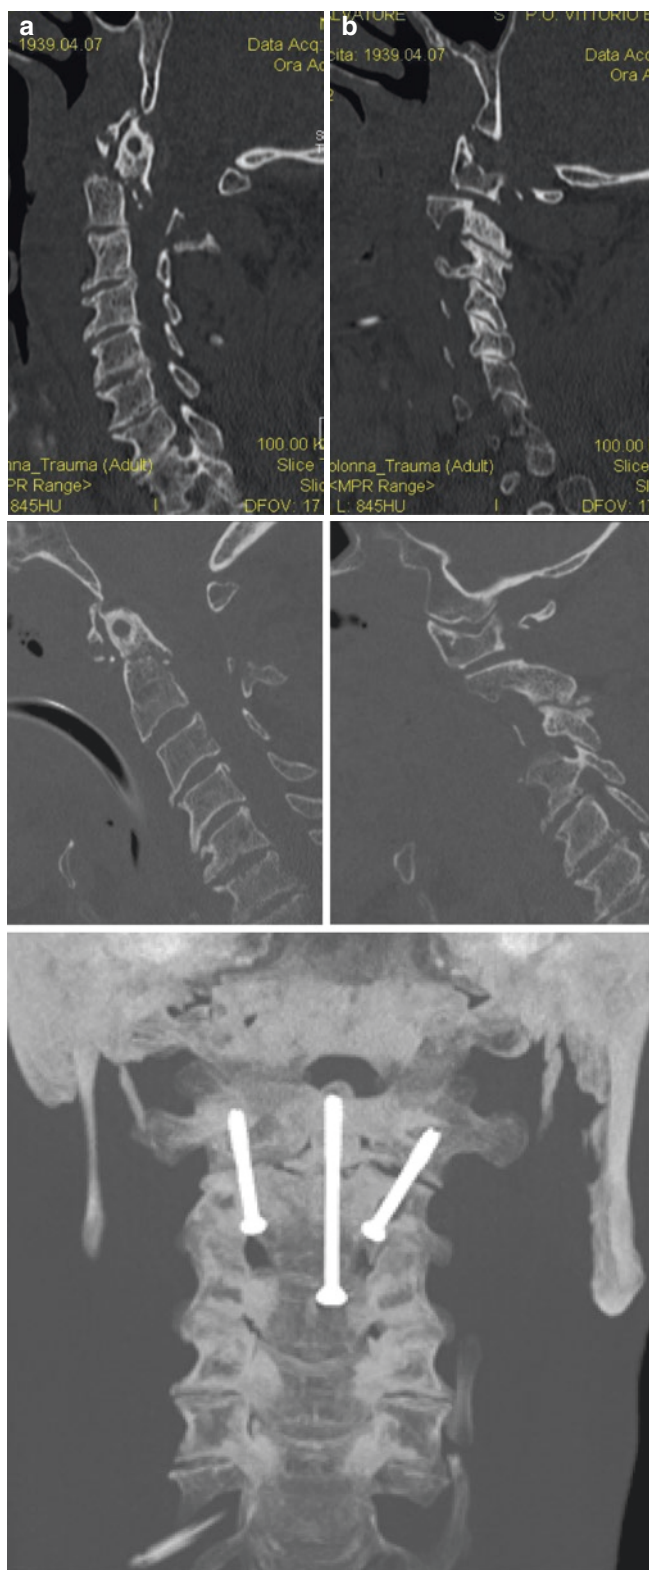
Computed tomography (CT) scan on admission, showing an odontoid fracture with 10-mm posterior dislocation of the fractured dens and of the C1 articular facet with respect to C2 (a, b). CT reconstruction after manual reduction, demonstrating good alignment (c, d). Postoperative three-dimensional CT scan (e)
